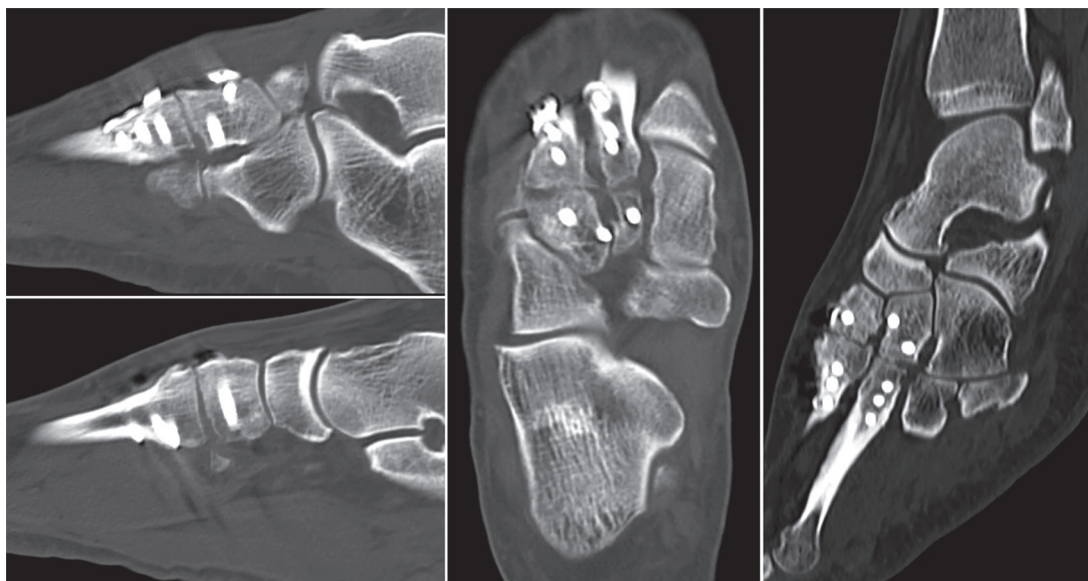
Axial and sagittal CT slices through a foot 12 months postsurgery where a combined plating technique has been used; this shows the nonunion of the second TMT joint and partial union of the third TMT joint
